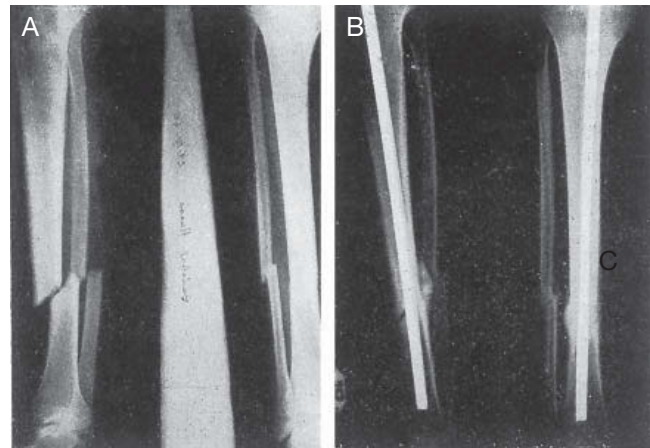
C.H.G. Closed oblique fracture, junction of middle-third and lower tibia and tibia. A: Fracture x-rays. B: Radiographic view at 3 months.
